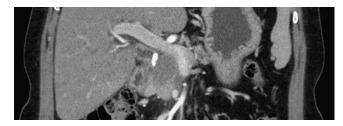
Multiplanar reconstruction of the axial computed tomography image in the same patient as in Figure 14.3 along the portal vein and superior mesenteric vein (SMV). Invasion of the SMV is seen on this image.
